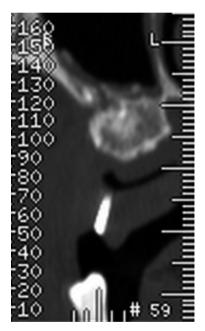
Post-op CT scan, control side.
